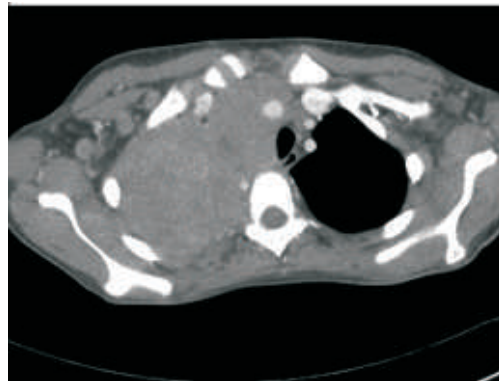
CT Chest demonstrating tumor in the mediastinum along with compression of trachea
